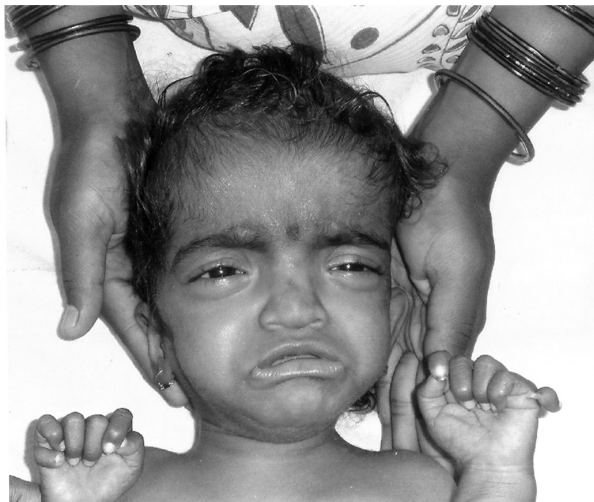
Acrocallosal syndrome, Note the hypertelorism, downslanting palpebral fissures, broad nasal bridge and short philtrum. Post axial polydactyly is seen in both the upperlimbs. MRI revealed absent corpus callosum.
